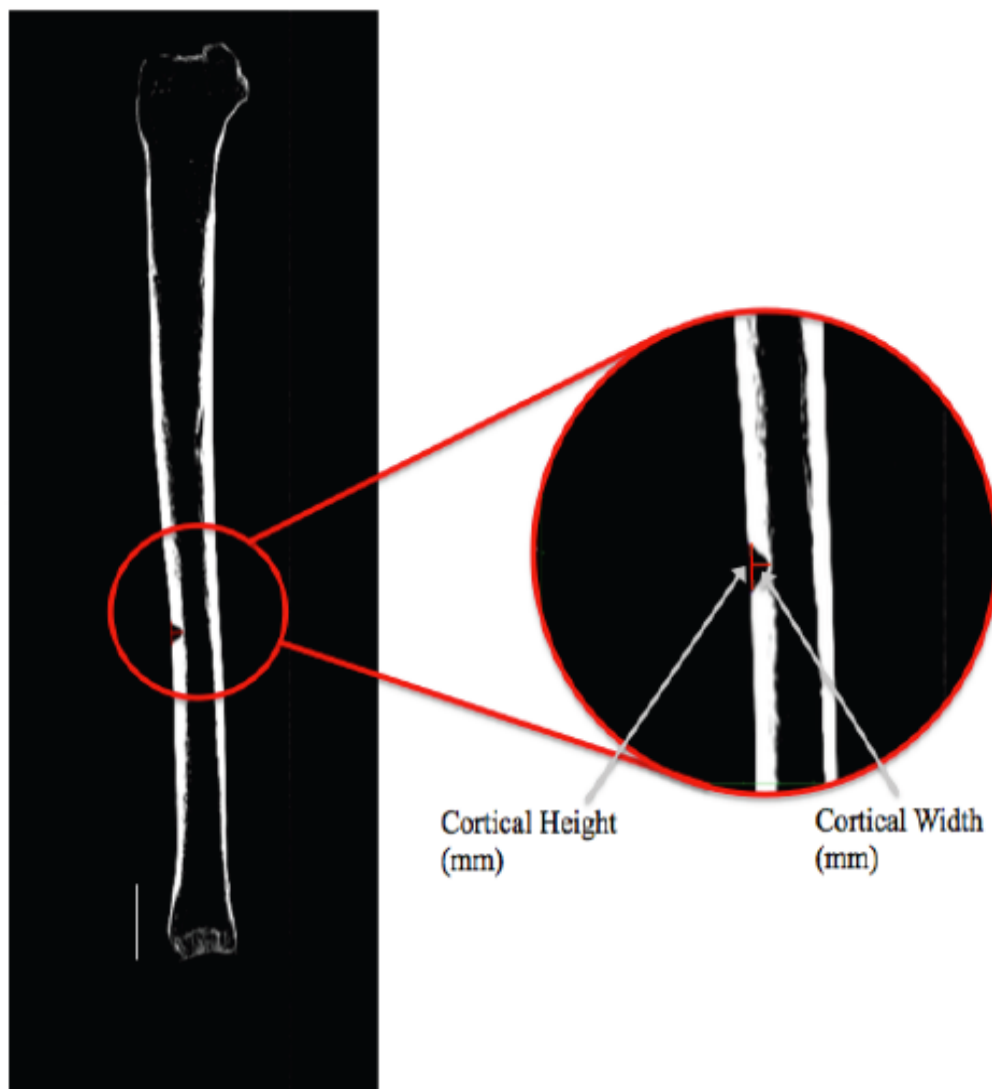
DICOM image from OsiriX software of a left tibia from a single CT projection. The circular window indicates the DNA sampling site. The superimposed enlargement displays the cortical height and width measurements (mm). Scale =400 mm. (Credit: JM. Andronowski).
